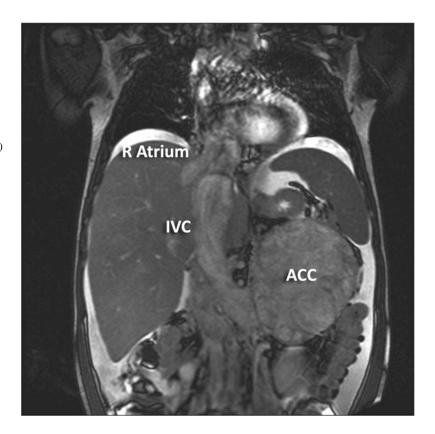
An 11-year-old female presented with a large left sided abdominal mass. a Axial CT scan with a 10.1 X 10.2 cm heterogeneous left adrenocortical carcinoma (*) displacing the pancreatic tail superiorly and the left
